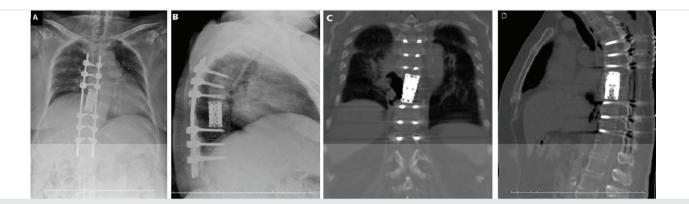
(a, b) Post-operative 3rd-month AP-lateral X-ray showing the T4-11 screw rod system (black arrow) and T7-8 corpectomy cage (green arrow). (c, d) Early post-operative coronal and sagittal MPR-CT showing proper positioning of the T4-11 screw rod system (white arrow) and the T7-8 corpectomy cage (blue arrow) MPR-CT: Multi-planar recon-computed tomography
